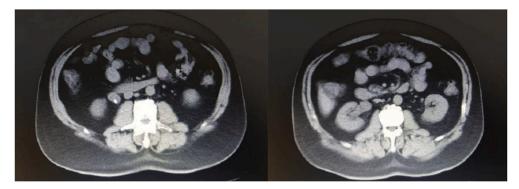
Computed tomography shows right renal hydronephrosis with ureteral stone.
